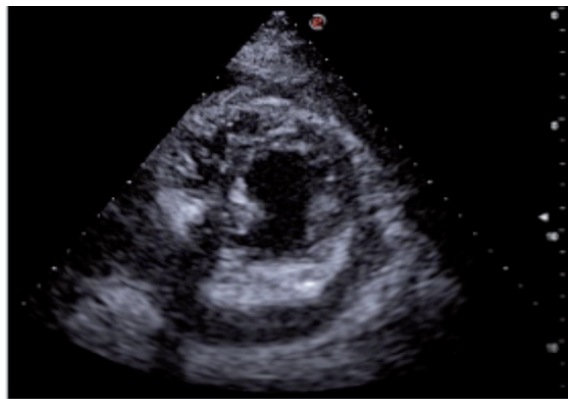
Parasternal short axis echocardiographic view showing circumferential pericardial effusion; maximal tele-diastolic size 13 mm.
